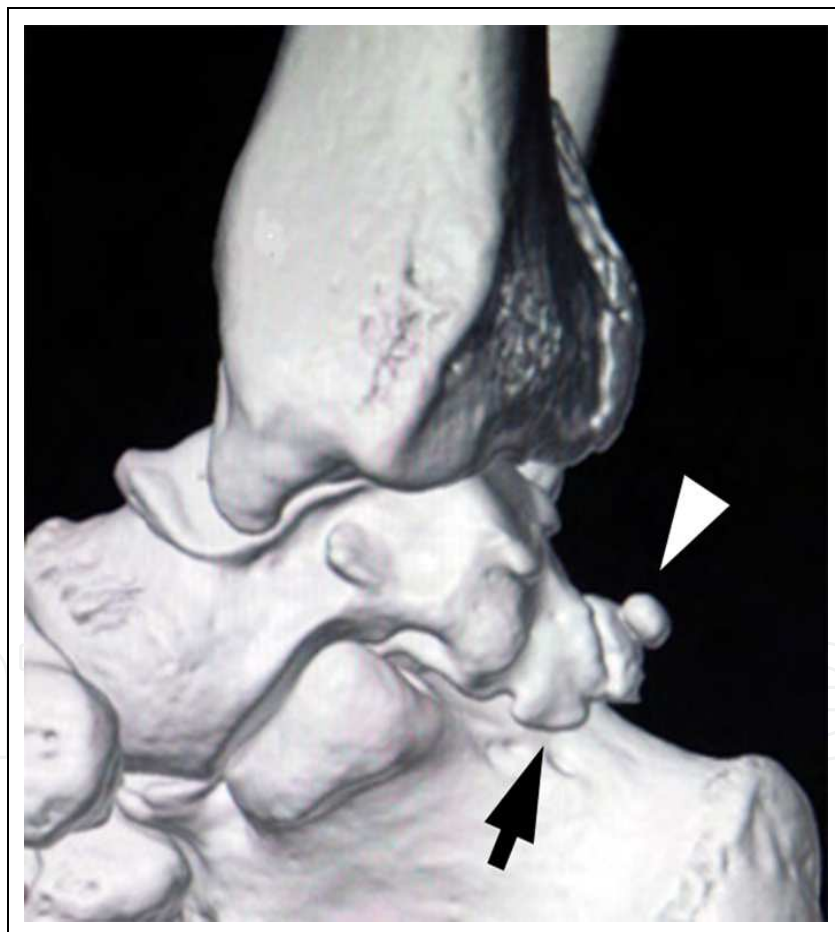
Three dimensional computed tomogram of the hindfoot.
